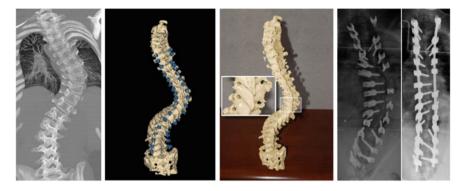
Pre-operative thick maximum intensity projection CT of patient with severe progressive scoliosis, rendering of 3D templating results developed with the spine surgery planning tools, the physical model printed from the plan, and the inter-op, post-operative radiographs
